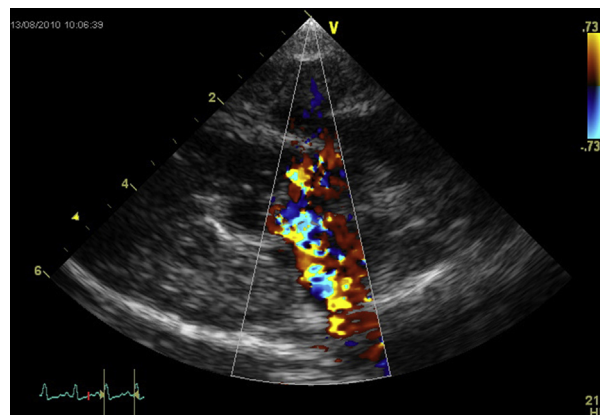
Color Doppler echocardiographic image from the right parasternal 5-chamber view in the same 8-year old Papillon from Videos 1 and 2 (case 1). There is mitral insufficiency and turbulent flow in the left ventricular outflow tract.
